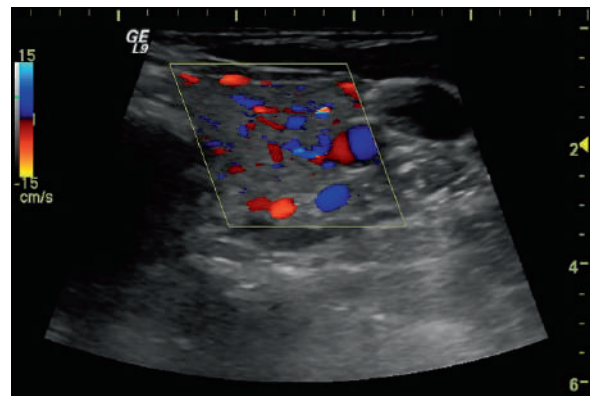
Color Doppler (Duplex) scan of the thyroid in a patient with Grave's disease shows marked vascular signal due to bruit (thyroid inferno sign)
